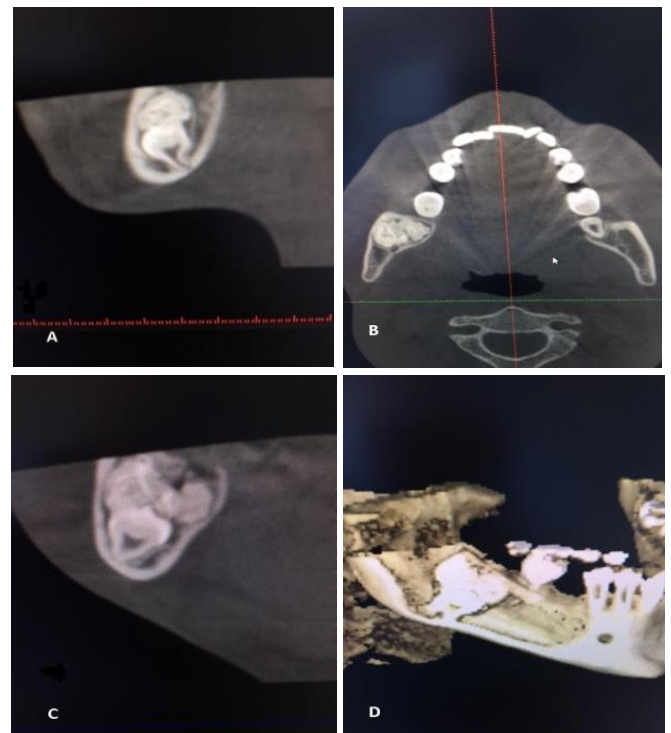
A. Sagittal section of CBCT shows the relation of the impacted third molar tooth and the lesion. B. Axial section of CBCT shows a slight buccolingual expansion of the mandible. C. Coronal section of CBCT shows similar features of the axial and sagittal sections. D. Three-dimensional image of the lesion in the lateral view shows the lesion and the impacted tooth.
